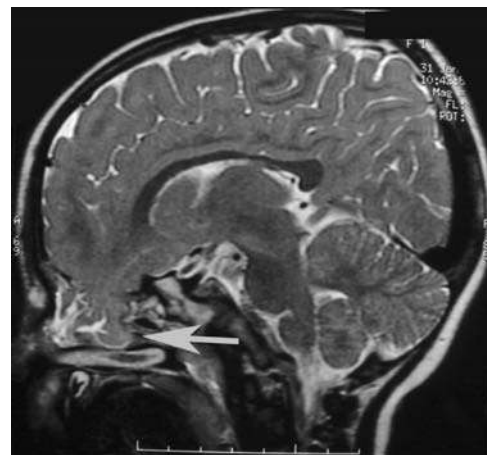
Sagittal MRI imaging shows a protruding mass from frontal lobe downward (*arrow*).
